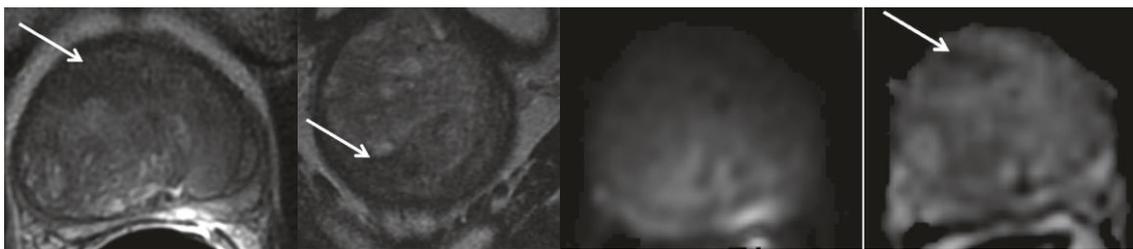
PI-RADS 3 category in TZ. First, axial T2WI. Second, coronal T2WI. Third, b1400 DWI. Fourth, ADC map. There is a heterogenous low signal intensity area in the right TZ with obscured margins without restriction. The DWI score is <4. Obtained from (12).
